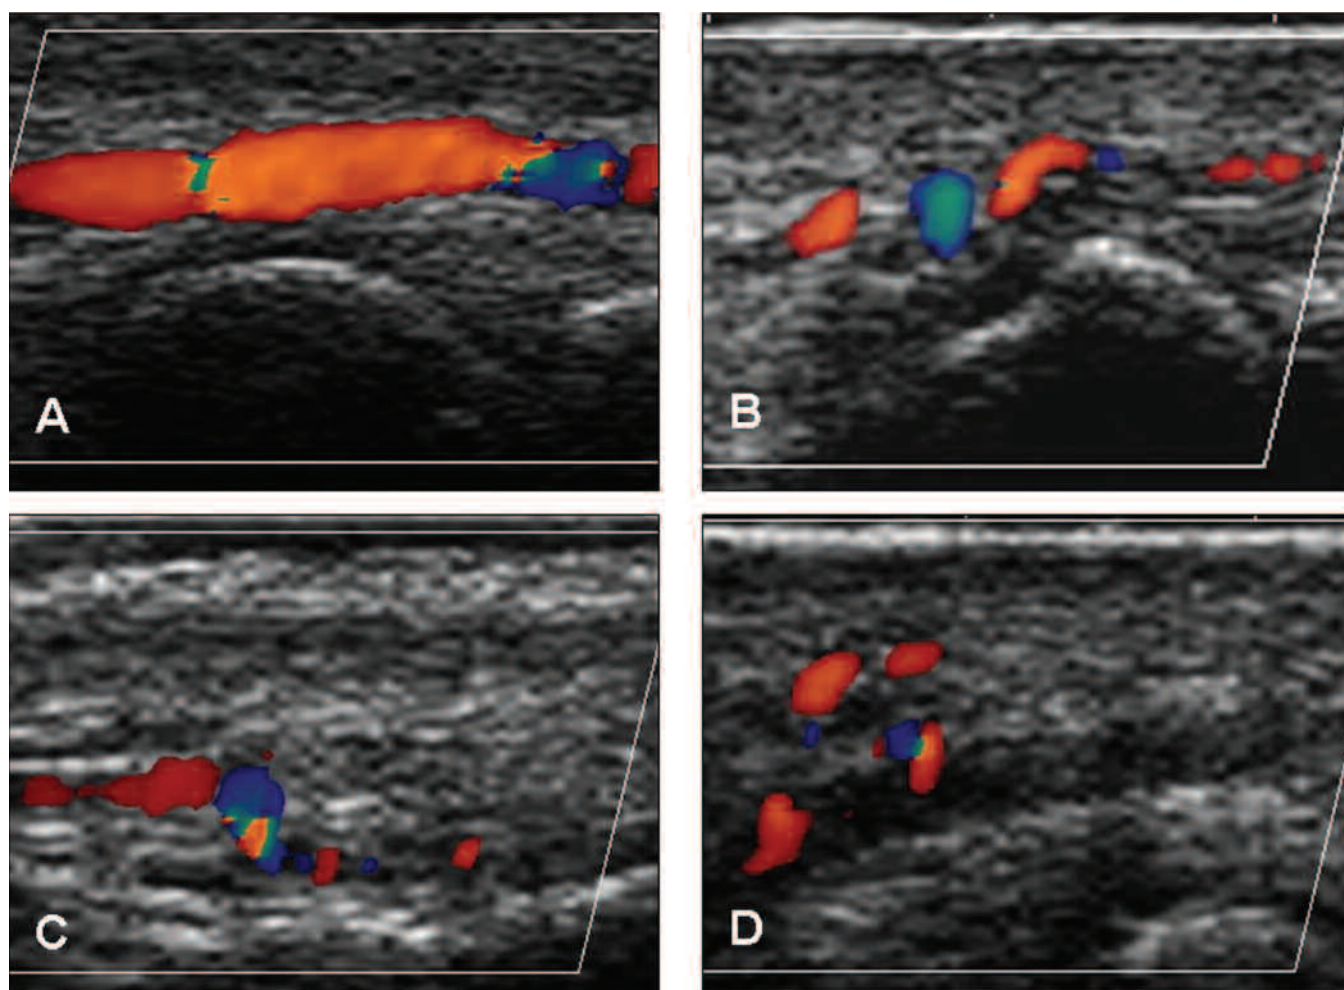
Color Doppler ultrasound longitudinal images of finger arteries proximally to or at the PIP joint. A. Normal left second ulnar proper palmar digital artery; B. Narrowing of the right fourth radial proper palmar digital artery in systemic sclerosis (patient with type 2 pathology); C. Chronically occluded right second ulnar proper palmar digital artery in APS. Collateral flow appears in the lower part of the image (patient with type 1 pathology); D. Acute occlusion of the right fourth radial proper palmar digital artery in Wegener's granulomatosis (patient with type 3 pathology). The dark structure in the middle of the image represents the occluded artery. The color above the artery represents collateral flow [original size: 254 × 190 mm (72 × 72 DPI)].
